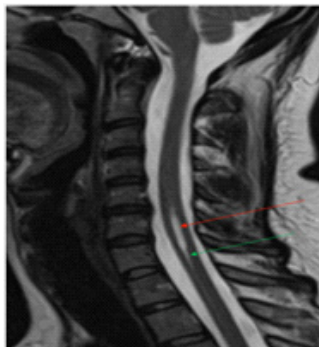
Sagittal T2 MRI of the cervical spine demonstrating a hyperintensity within the cord at C6-C7 level (red arrow). Note the “continuation” of signal from the central canal best demonstrated at the inferior margin (green arrow).
